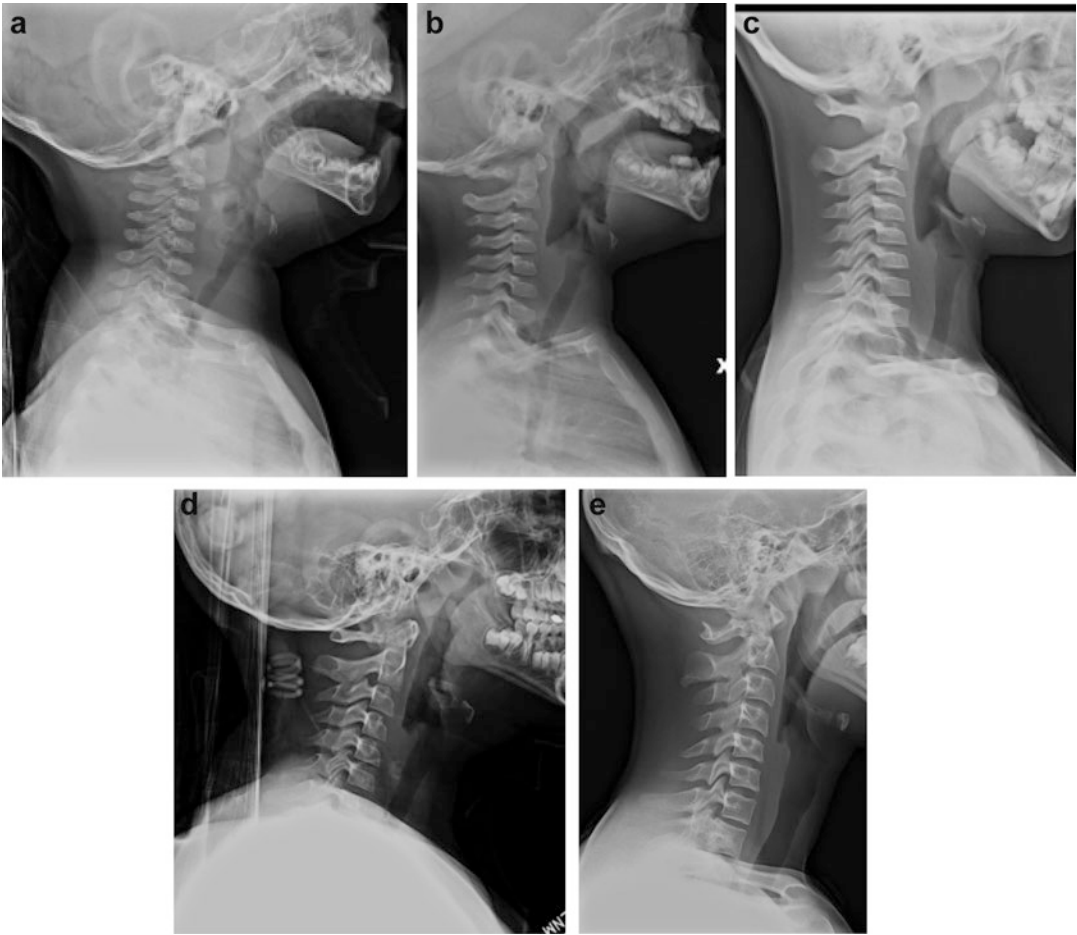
(a) Lateral radiographs as children skeletally mature. Age 6 months, (b) 2 years, (c) 6 years, (d) 9 years, (e) 16 years
